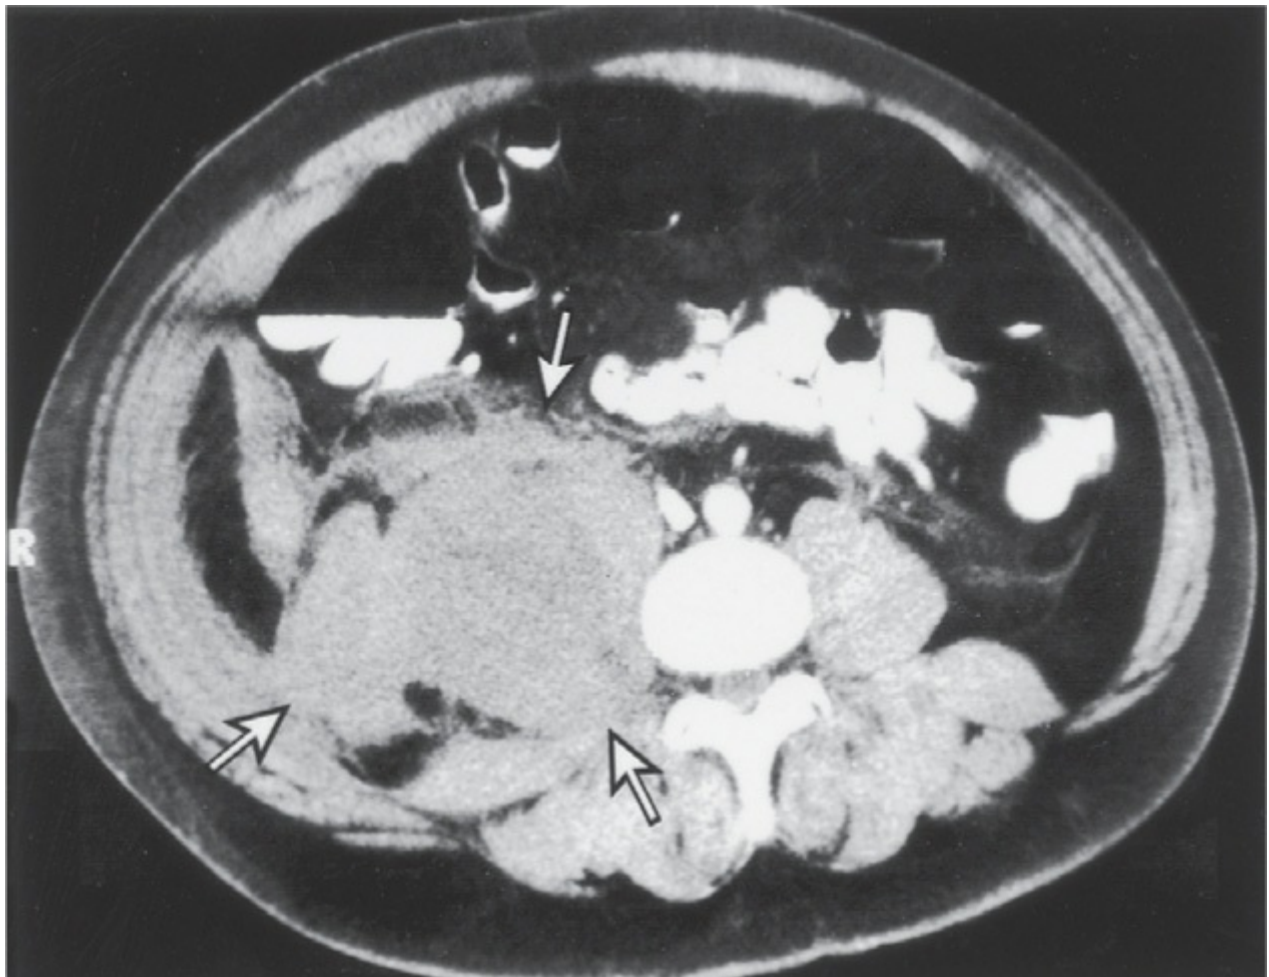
Computed tomography scan of a retroperitoneal hematoma in a patient with severe hemophilia A. Extent of the hematoma is indicated by the *arrows*. (Reproduced, with permission, from Roberts HR, Key NS, Escobar MA. Hemophilia A and hemophilia B. In: Lichtman MA, Kipps TJ, Seligsohn U, et al, eds. *Williams Hematology*. 8th ed. New York: McGraw-Hill; 2011.)
